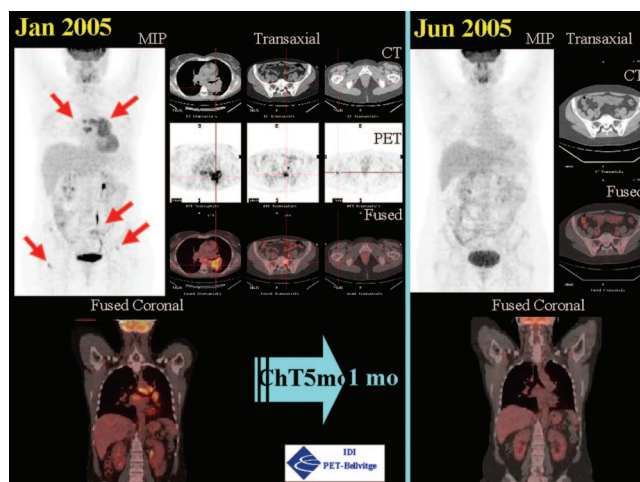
A 42-year-old woman with small-cell lung cancer referred for primary staging. Positron emission tomography/computed tomography imaging shows extensive disease involving the left lung, mediastinum, and bone, as shown in the left sacrum and the right femur. She received chemotherapy for 5 months, and restaging with a PET/CT 1 month after the completion of treatment showed a complete remission.
